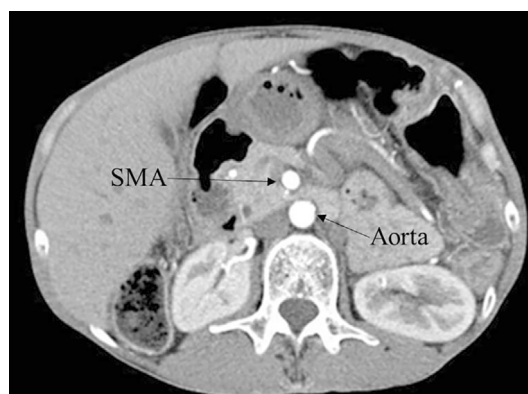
An abdominal transverse image from CECT for measuring the distance between the SMA and aorta where the duodenum passes. This is a transverse image of the patient shown in Figure 1. The distance between the SMA and aorta measured on this slice was 9 mm. CECT: contrast-enhanced computed tomography, SMA: superior mesenteric artery
